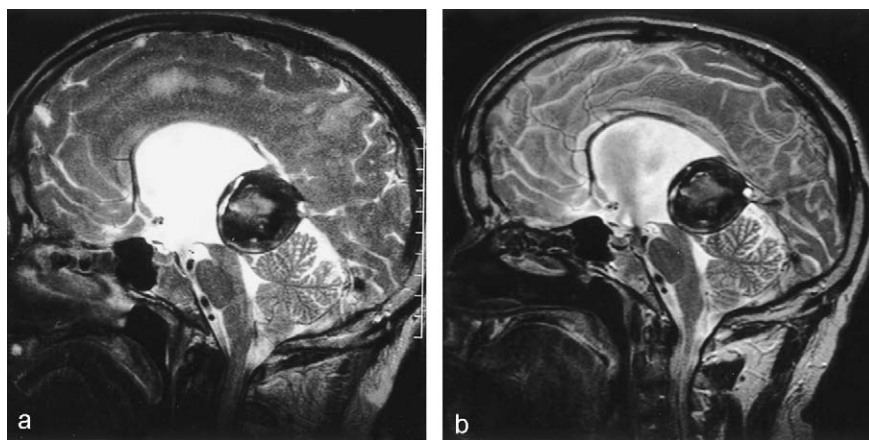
a Preoperative T₂-weighted sagittal MRI, showing the mass effect exerted by the ectasia of the vein of Galen. The vascular malformation occludes *aditus aquaeducti* pushing down the *colliculi* resulting in blocked hydrocephalus. b Postoperative T₂-weighted sagittal MRI confirms the good CSF flow through the stoma on the floor of the third ventricle without a significant variation of the ventricular diameters.
